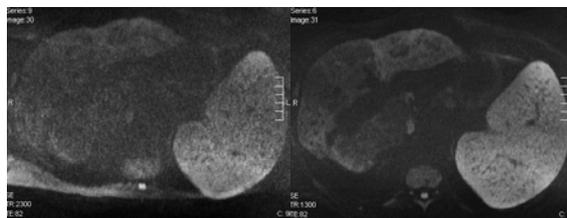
Cirrhotic patient imaged with BH (left) and NBH DWI (right) at b500. Note the superior image quality and higher signal with NBH acquisition. Geographic signal changes in liver parenchyma are better depicted on the NBH image.
